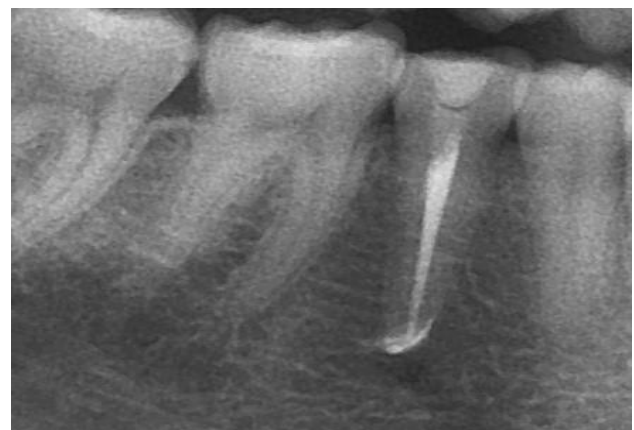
2-year follow-up radiograph.
